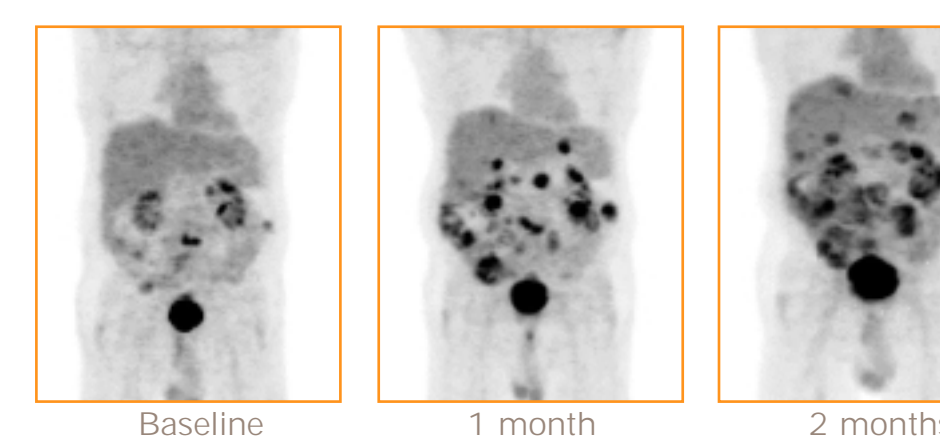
FDG-PET studies in the only patient who progressed following the initiation of STI571 therapy showing progressive FDG-avid disease in the liver, abdomen, and pelvis over time.
